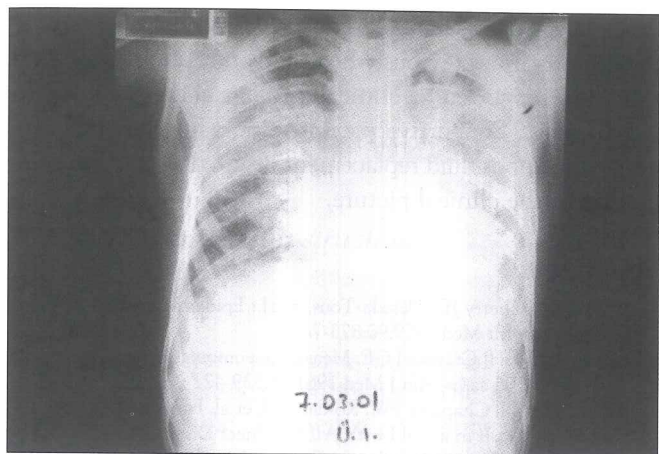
Chest x-ray on admission showing diffuse bilateral alveolar opacity throughout the lungs.
